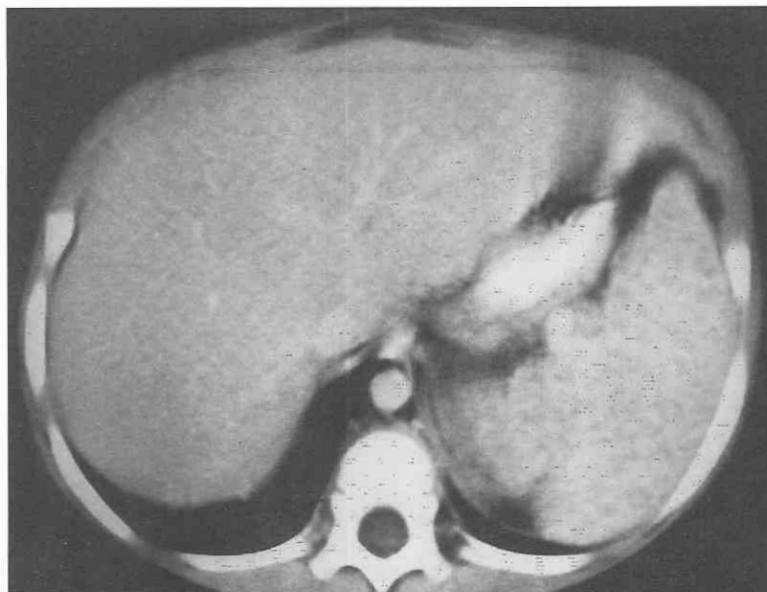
Candidiasis of the spleen in a 2-year-old boy with acute myelogenous leukemia undergoing chemotherapy. Helical CT image reveals the typical low-density appearance of numerous small abscesses in the spleen due to *Candida albicans* infection. Although the liver is typically coinfectd in candidiasis, there were no abscesses seen in this child's liver at CT examination. Multiple abscesses, however, were also seen in both kidneys at CT.
